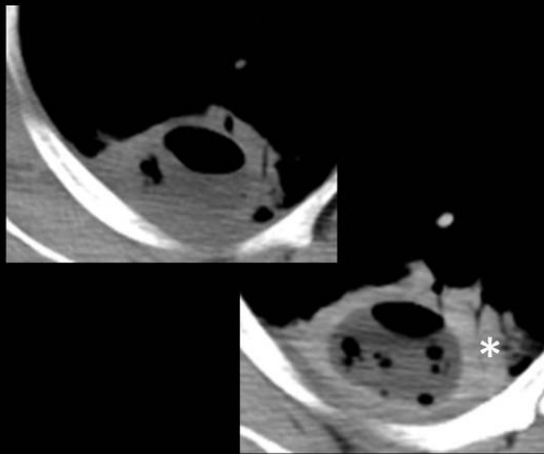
57 year-old diabetic patient, with fever, cough, dyspnea and foul expectoration. Axial CT images show a fluid-filled abscess on the right lung with small amounts of air inside it. After contrast administration (b), a enhancing wall is visible and there is surrounding consolidated lung (*), a clue to the inflammatory etiology of this lesion.
